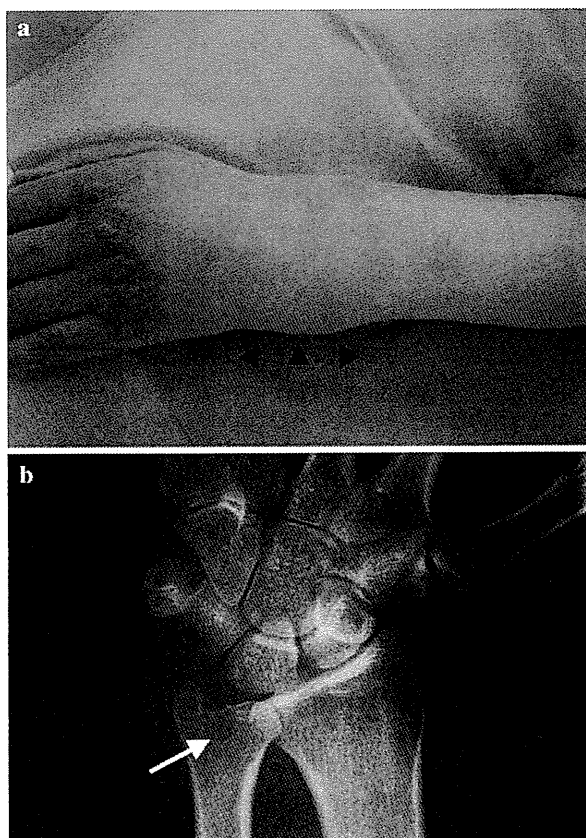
Clinical manifestation and X-ray of the left wrist joint. a Left hand with an elastic soft tumor on its dorsal aspect (*arrowheads*), b X-ray. An *arrow* indicates the erosive lesion of the distal ulna
